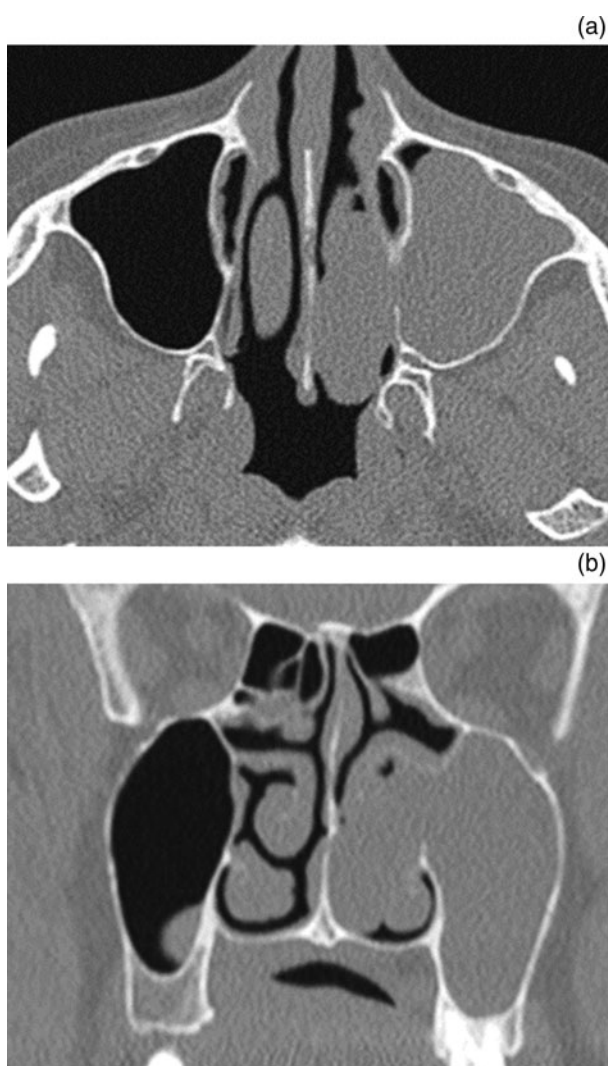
Computed tomography of paranasal sinuses showing soft tissue opacity filling the maxillary sinus and nasal cavity in (a) axial plane and (b) coronal plane.
